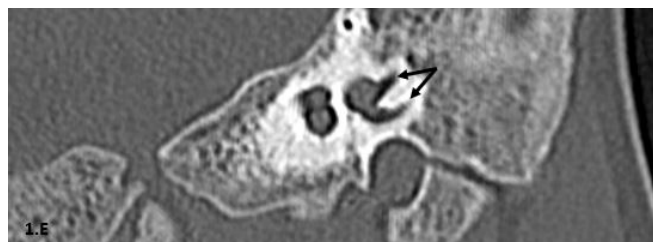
E: left coronal oblique CT bone window revealed average semicircular canals (black arrows).
